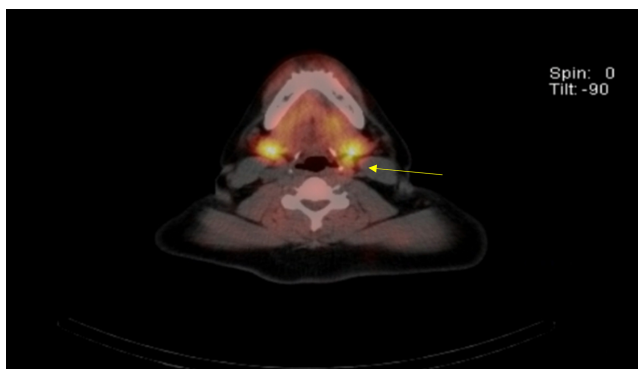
Sestamibi Single Photon Emission Computed Tomographic (SPECT/CT) Study. Yellow arrow points to the candidate lesion.
